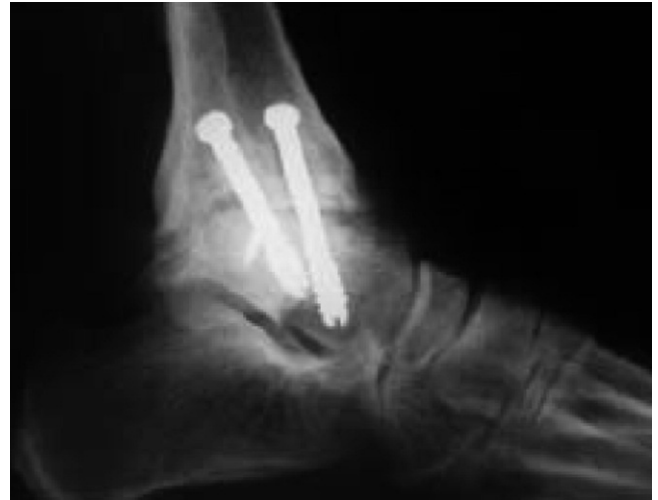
Lateral ankle weightbearing x-ray, 3 months post operative film.
